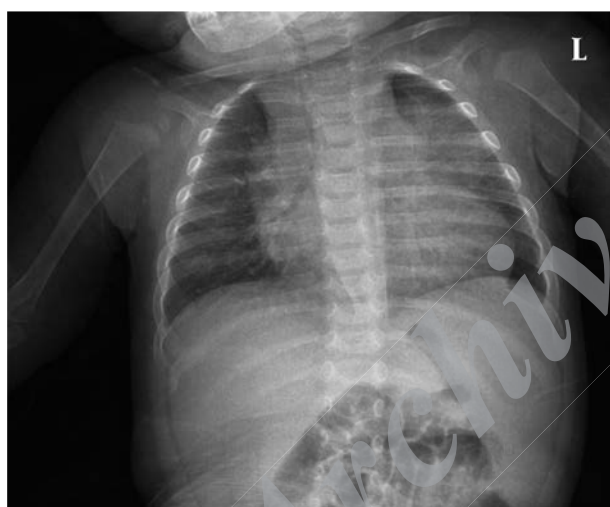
Chest X-Ray Image
